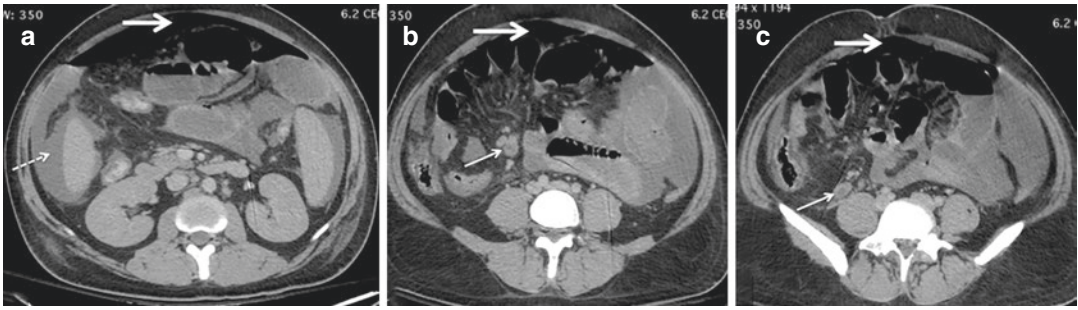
26-year-old man who presented with acute abdominal pain. (a–c) Axial contrast-enhanced CT images show free air in the nondependent part of the peritoneal cavity (thick solid arrows). Moderate ascites (dashed arrow) and multiple enlarged mesenteric lymph nodes are
